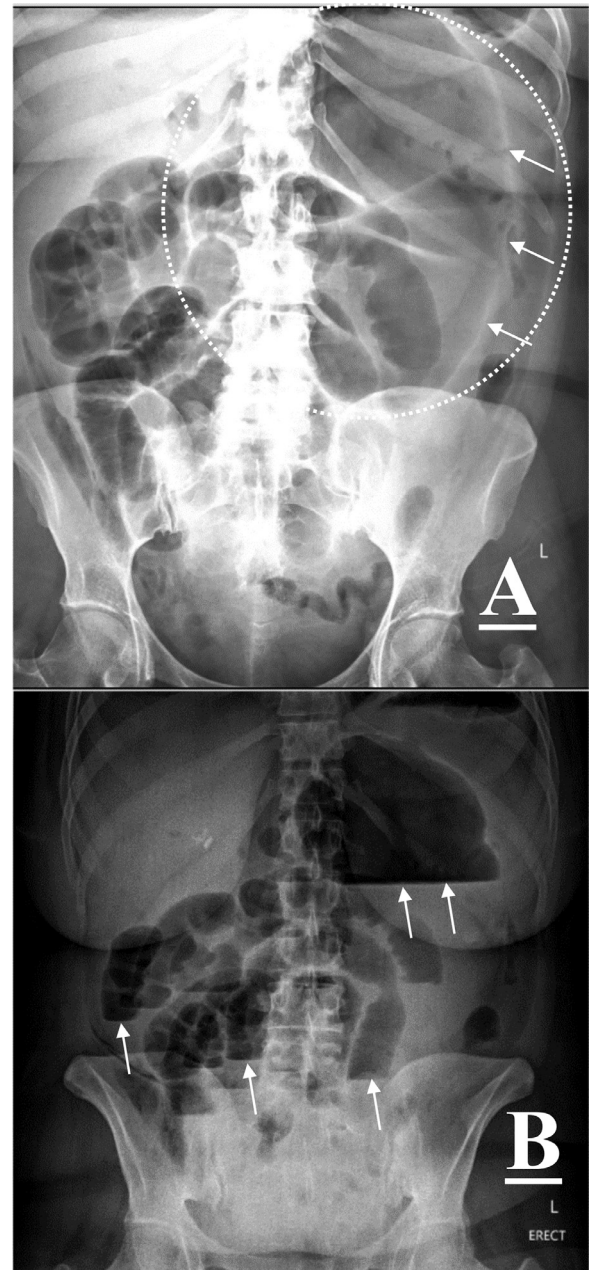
(A) demonstrates supine abdominal X-ray; the white arrows point to the edges of the dilated cecum anchored by the dotted white circle. (B) demonstrates erect abdominal X-ray, the white arrows show multiple air fluid levels in the small and large bowel loops.
